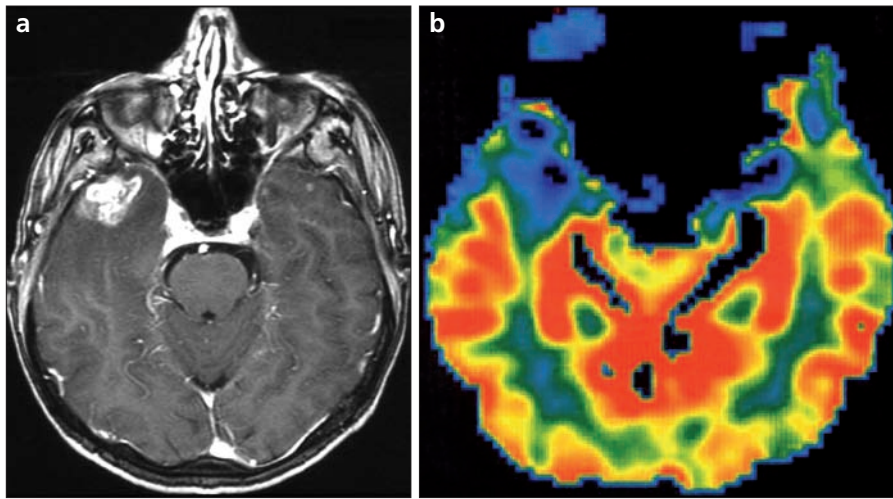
a, b. Post-contrast transverse T1-weighted MR image (a) shows bilateral (left is not shown here) radionecrosis in the temporal lobe of a patient treated for nasopharyngeal carcinoma 2 years ago. Perfusion MR study (b; obtained with echo-planar-imaging gradient-echo sequence) reveals the hyperperfused nature of the radionecrosis, differentiating it from a space-occupying malignant lesion.
